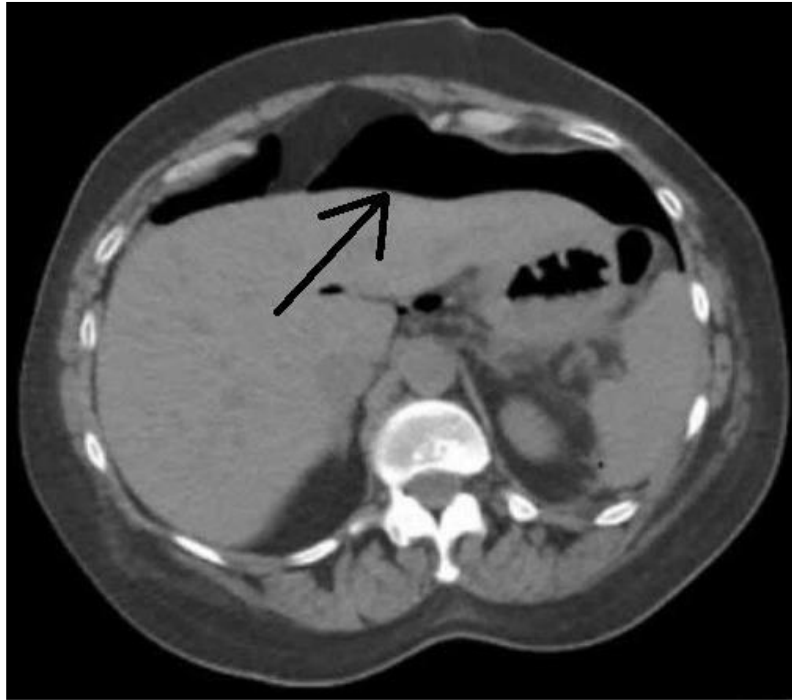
CT scan of the abdominal organs, axial projection. Free gas (arrow) in the abdominal cavity of a wounded man in the abdomen.
